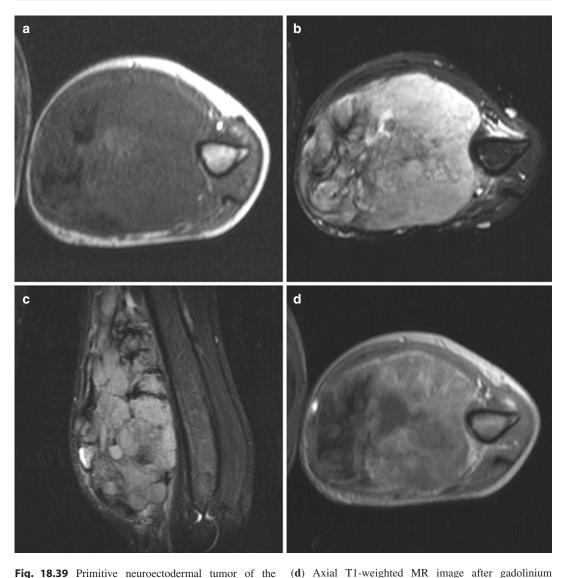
Primitive neuroectodermal tumor of the medial upper extremity of a 20-year-old patient with neurofibromatosis type I. (a) Axial T1-weighted MR image. (b) Axial T2-weighted MR image with fat saturation. (c) Sagittal T2-weighted MR image with fat saturation.
